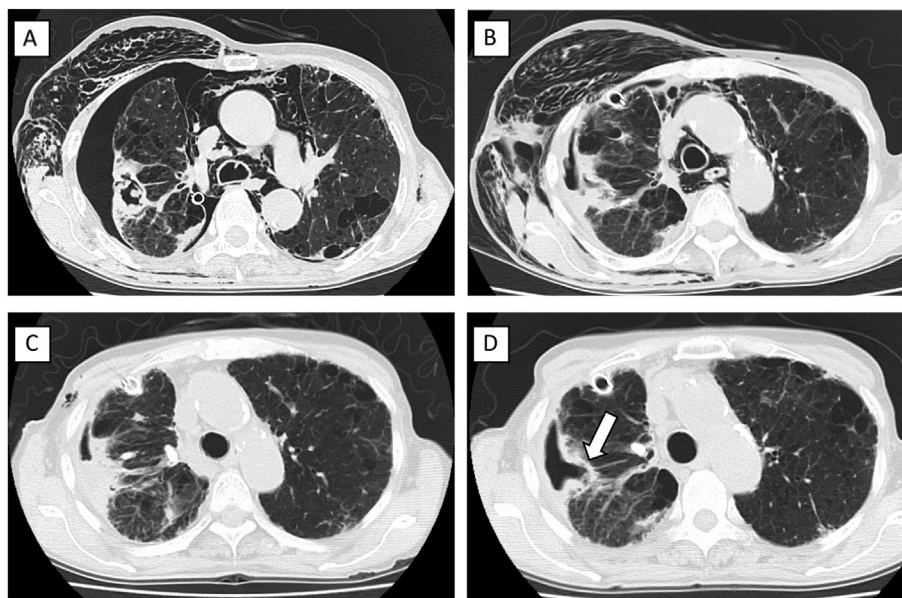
Chest Computed tomography (CT) images. (A) Day 1. Pulmonary emphysema and subcutaneous emphysema. (B) Day 14. *Aspergillus* empyema with rupture of aspergilloma cavity. (C) Day 27. Improvement in pneumothorax, but no improvement in empyema status with intravenous VRCZ administration. (D) Day 39. The disappearance of the fungus ball (open arrow) after four intrathoracic injections.
